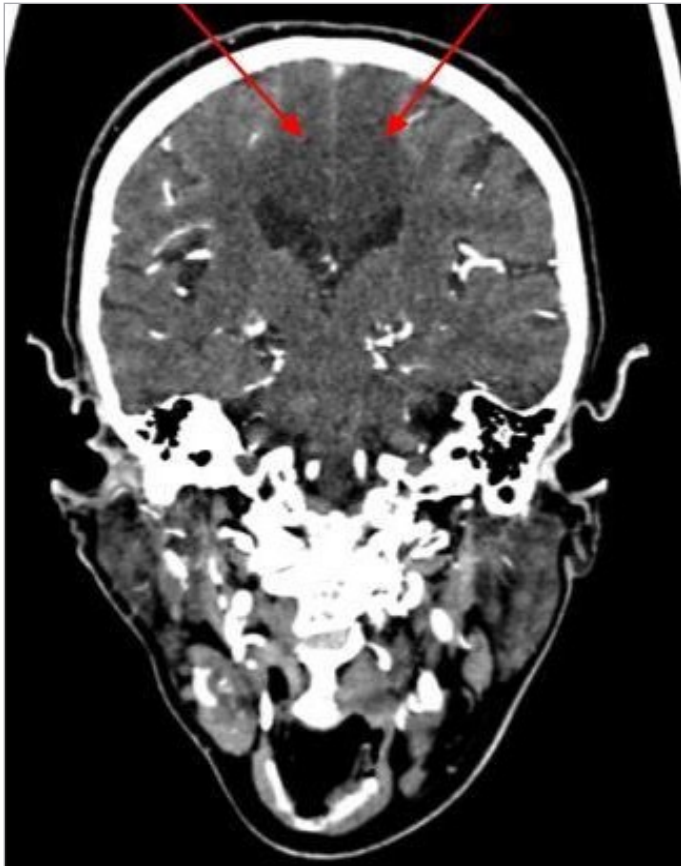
CT head scan showing the bilateral stroke.
